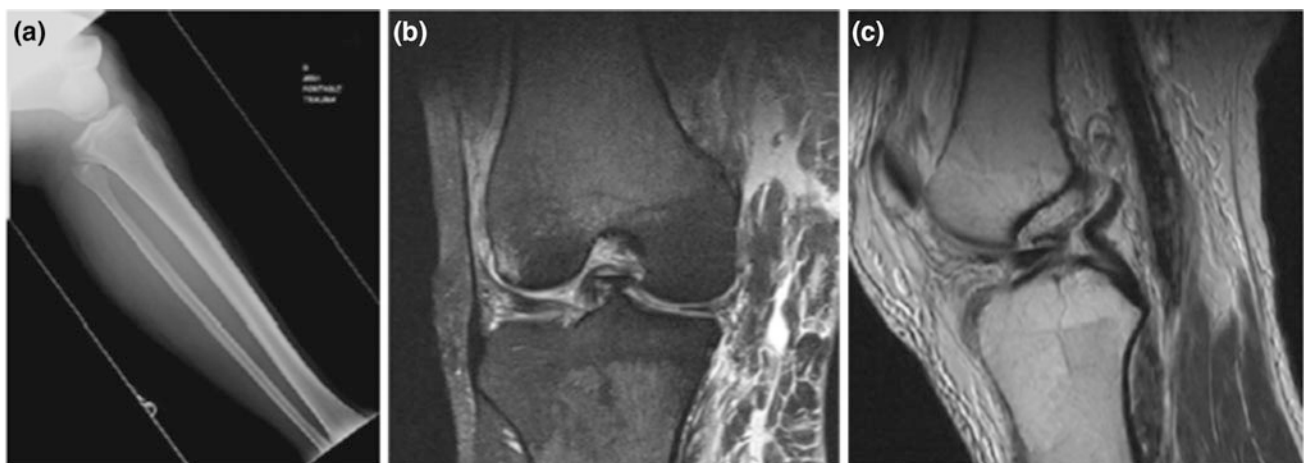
Spot radiograph of a knee dislocation (a). Coronal (b) and sagittal (c) intermediate-weight MRI images, of the same patient, showing torn ACL, PCL, and bucket handle meniscal tear. Coronal section shows injury to MCL as well
